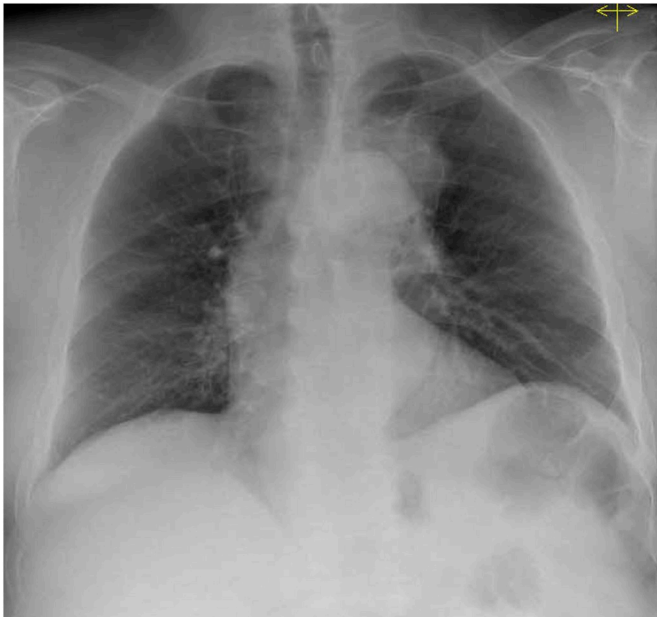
Chest radiograph (PA) view showing a lesion around aorta.
